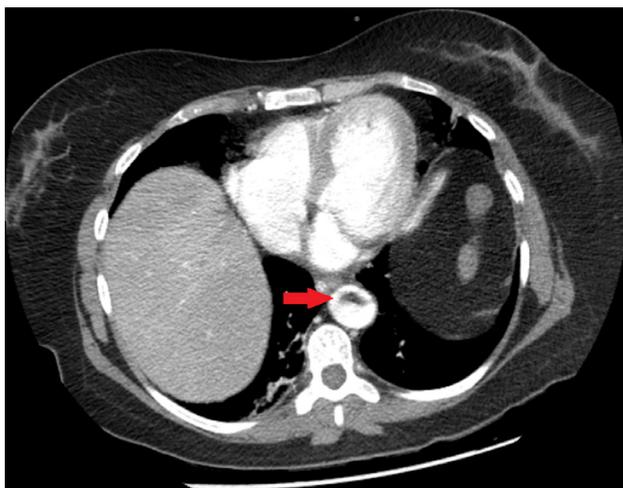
CT angiography, axial view. The red arrow shows an abnormal finding within the descending thoracic aorta.
